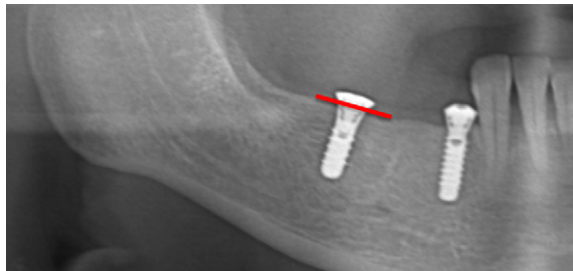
A transverse line was observed at the junction of the implant neck and cover screw and mesial and distal crestal bone levels were noted on the first postoperative radiograph.
